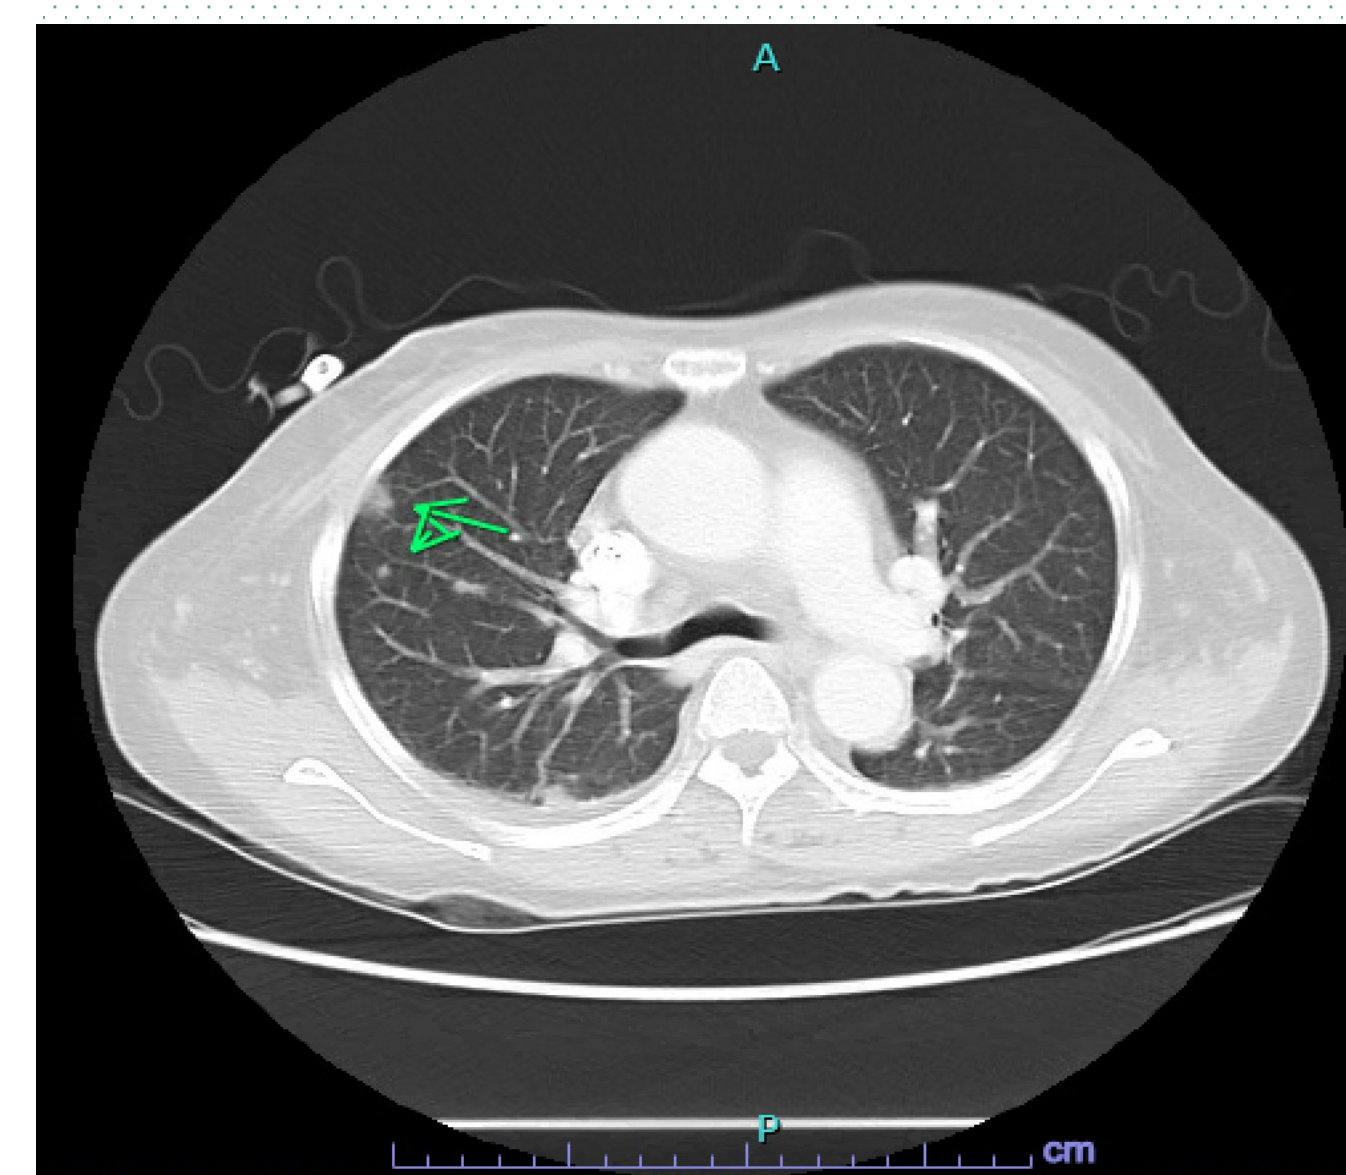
CT Chest w/ multiple ill-defined nodular opacity bilaterally concerning atypical pneumonia
